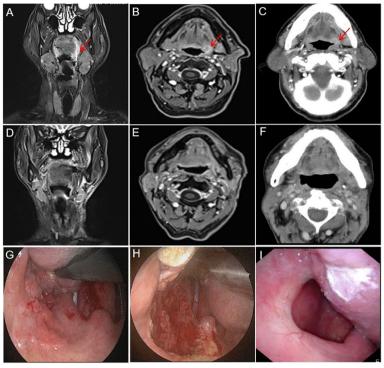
Cervical imaging and surgical field of vision of patients with oropharyngeal malignant tumor: The coronal plane (A) and transverse position (B) of preoperative neck CE-MRI show that the tumor on the left side of oropharynx-the left edge of tongue root-the back of soft palate shows uneven enhancement with unclear boundary (red arrow). C Preoperative CE-CT of the neck showed uneven thickening of the mucosa from the left wall of oropharynx to the left tongue root, and the enhanced scanning was obviously enhanced (red arrow). D-F Postoperative follow-up showed that no tumor recurrence was found in neck CE-MRI and CE-CT. G Displaying the lesion range of oropharyngeal tumor through oral endoscope. H Display the wound surface after tumor resection through oral endoscope. I 15 months after operation, the follow-up laryngoscope showed no recurrence of the tumor
